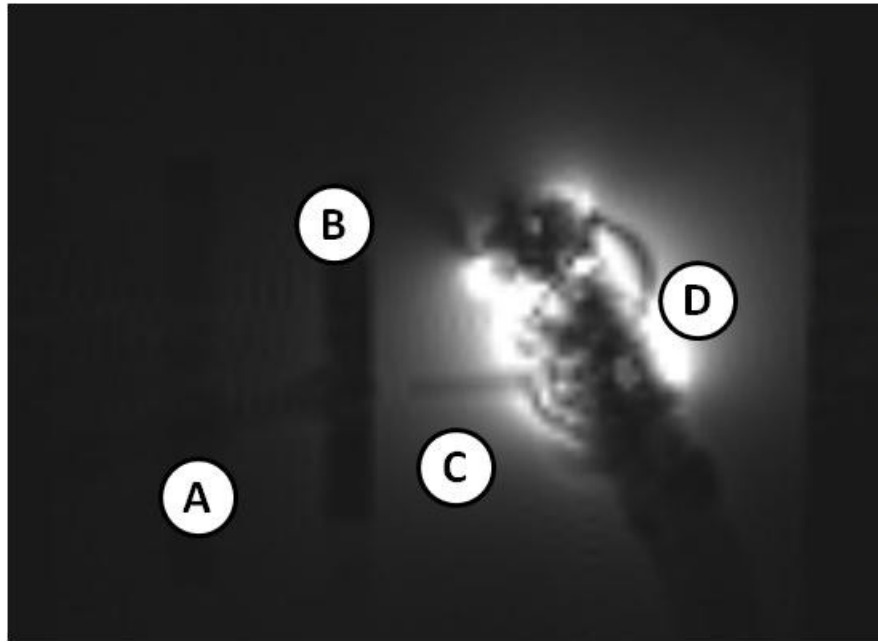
MRI guidance image showing (A) bile duct tube, (B) duodenum plate, (C) catheter and (D) duodenum with imaging coil.
